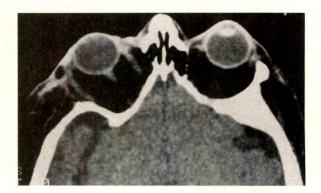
(Leone, Piest, and Newman). Left, Preoperative axial computed tomography of patient who had intermittent subluxation of right globe between her eyelids. Right, Postoperative scan showing prolapse of the orbital tissues into the lateral and medial decompressive spaces.
